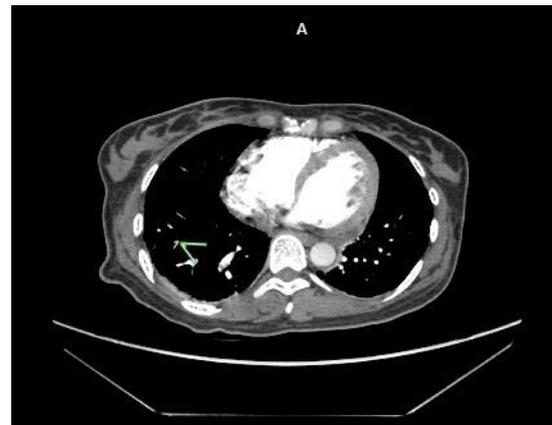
CT pulmonary angiogram (CTPA) displayed intraluminal filling defect at lateral and posterior right lower lung
